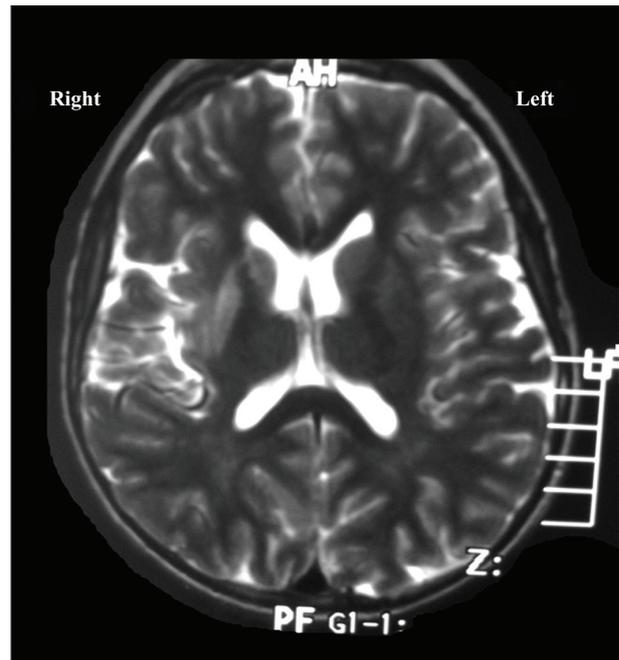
T2-weighted axial section shows right cerebral hemiatrophy predominantly in the perisylvian region; hyperintense lesions are also observed in this region.
